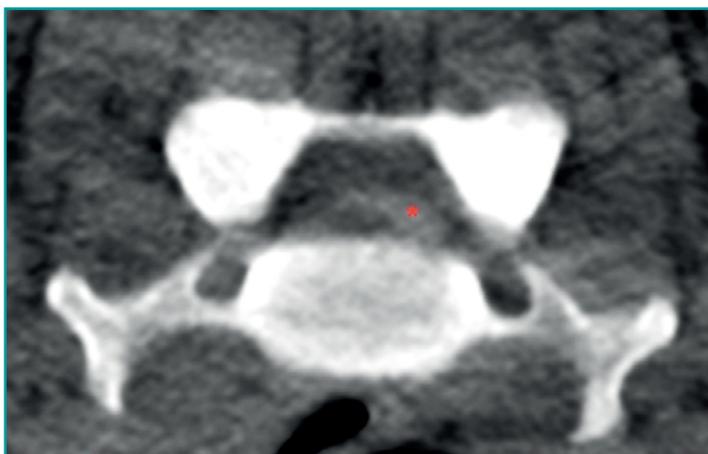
Transverse CT scan immediately cranial to the intervertebral space C5-C6; disc extrusion (asterisk).
